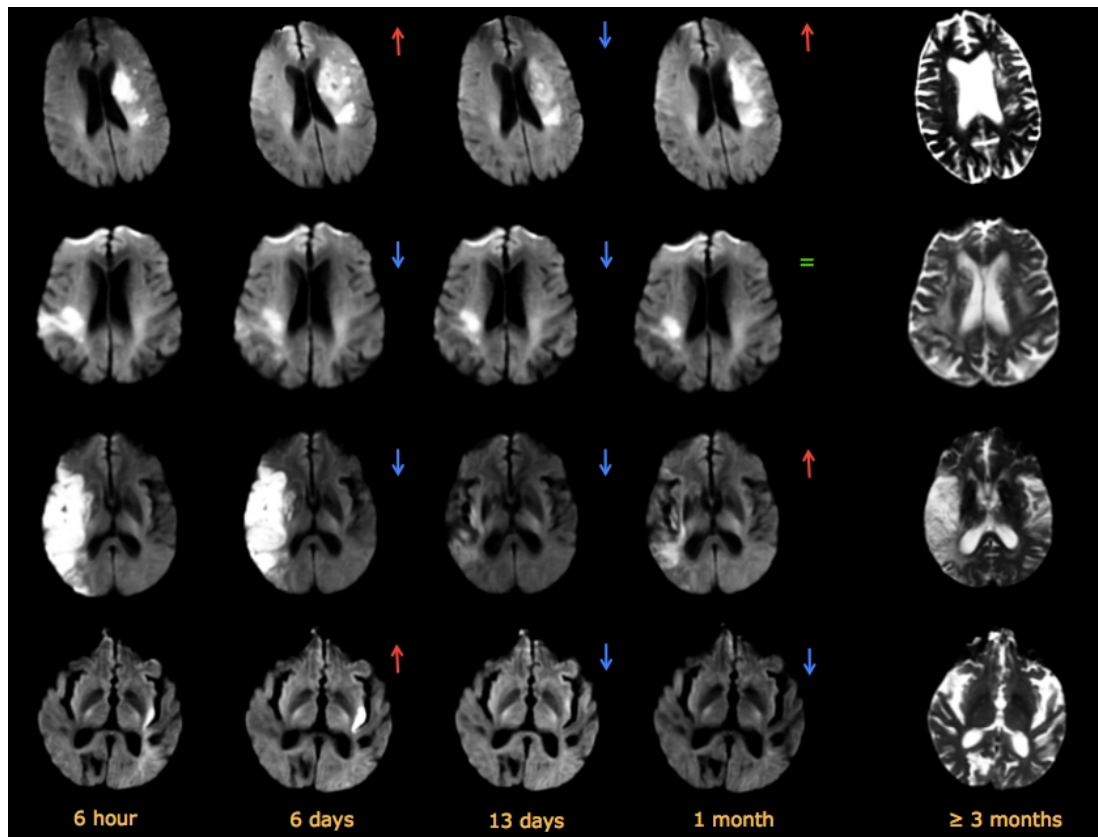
Lesion temporal change in 4 representative patients. The first four columns show the lesion changes on DWI images and the last one on T2-w final image. The red (vs. blue) arrow to the right of the MR axial slice indicates that the lesion has increased (vs. decreased or disappeared) when compared to the previous timepoint. The ‘equal green symbol’ indicates that the lesion did not change from the previous acquisition timepoint. The four displayed patterns of DWI lesion evolution are completely different.
